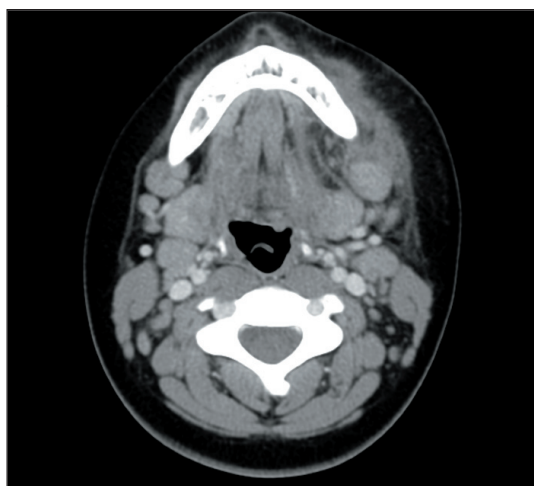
CT Scan showing soft tissue swelling and abnormal density on the left side.
